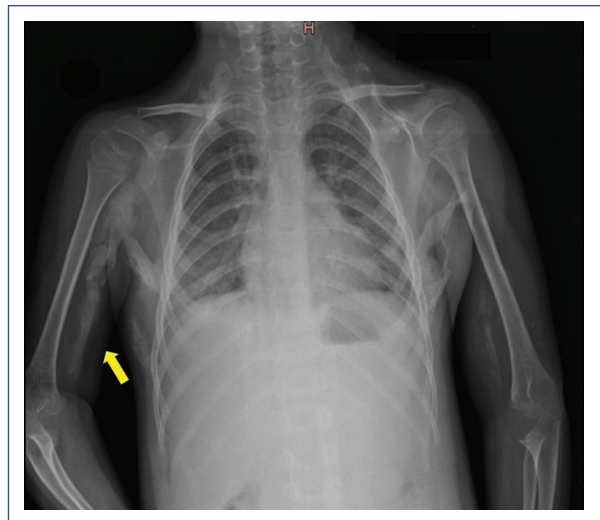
Radiographic evidence of ossification of the biceps brachii muscle.
